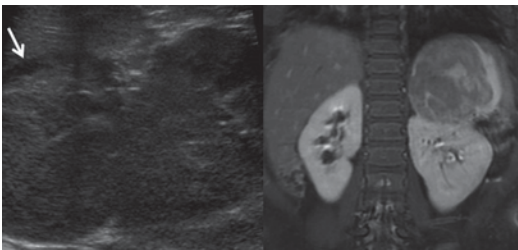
A 14-year-old female with hypertension and elevated urine metanephrines. Longitudinal ultrasound demonstrates a heterogeneously hypoechoic mass in the left adrenal gland. Sagittal T2-weighted fast spin-echo magnetic resonance image demonstrates a heterogeneously hyperintense T2 mass. Pheochromocytoma was confirmed at surgical resection
